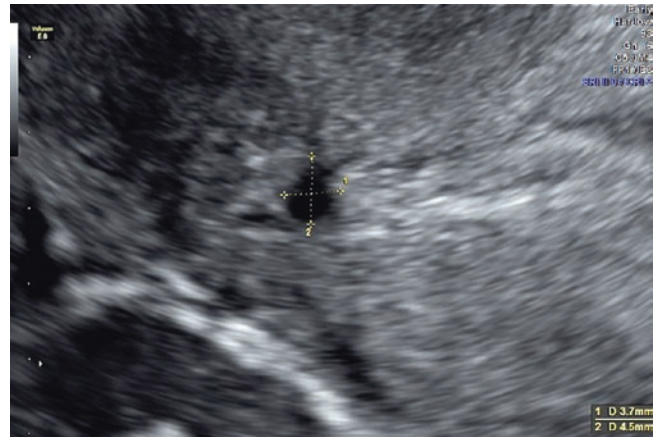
Transvaginal ultrasound view of the of the lower uterine segment in a 7-week pregnant woman 18 months after a previous emergency CS. Note a small scar defect in the superficial myometrium at the junction between the lower segment and the cervix
